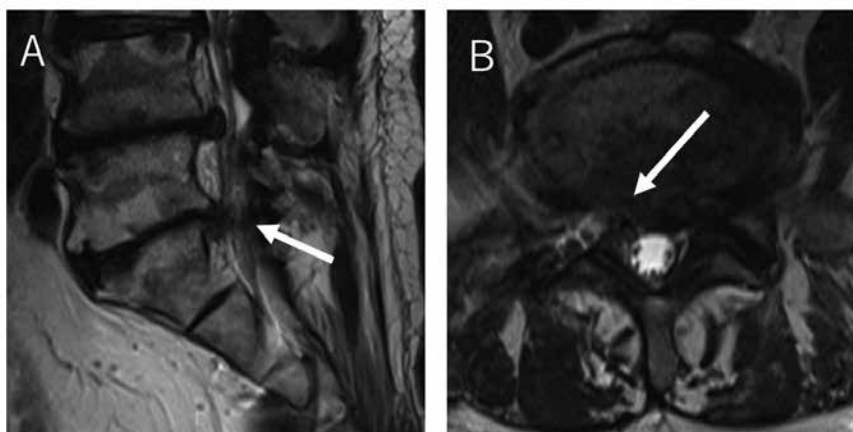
Magnetic resonance images obtained after surgery. Sagittal (A) and axial (B) images show that the herniated nucleus pulposus has been successfully removed (arrows).
